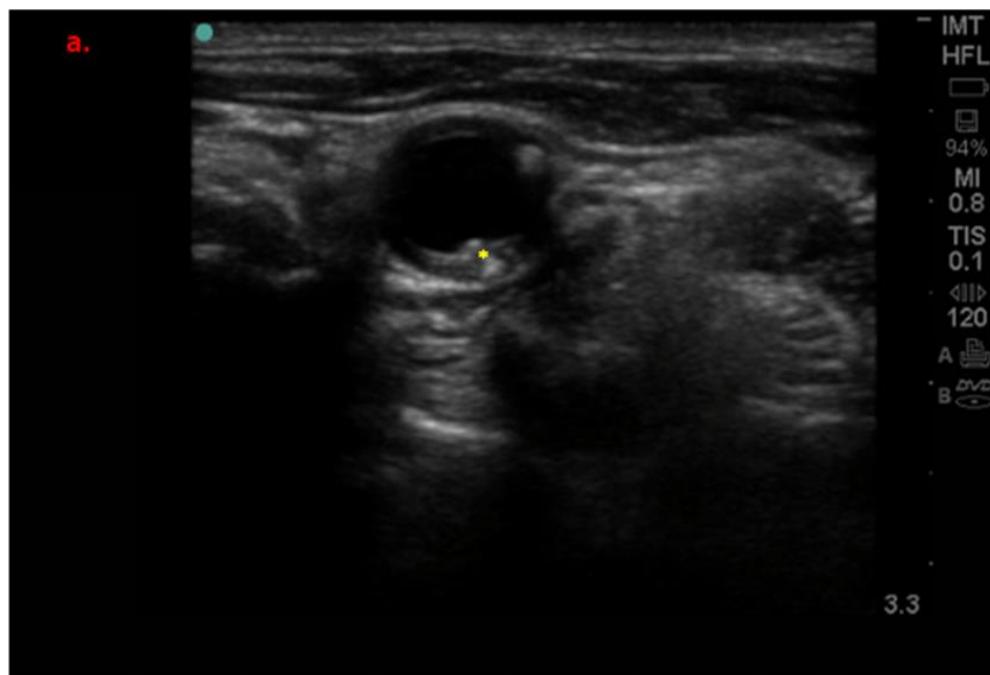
Ultrasonography showing the cross sectional (a) and longitudinal sections (b) in and around the carotid bifurcation for the identification of the presence of plaque (indicated by the yellow *).
